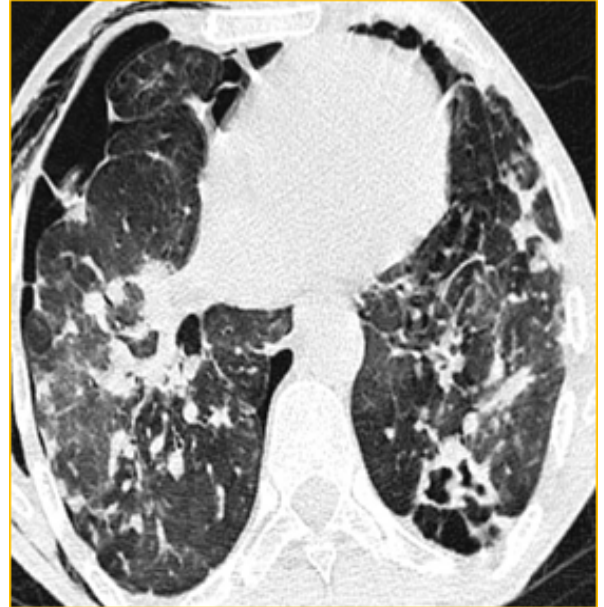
CT thorax lung window in axial view demonstrating Lung Cicatrization with spontaneous pneumothorax and subcutaneous emphysema on the right side.
